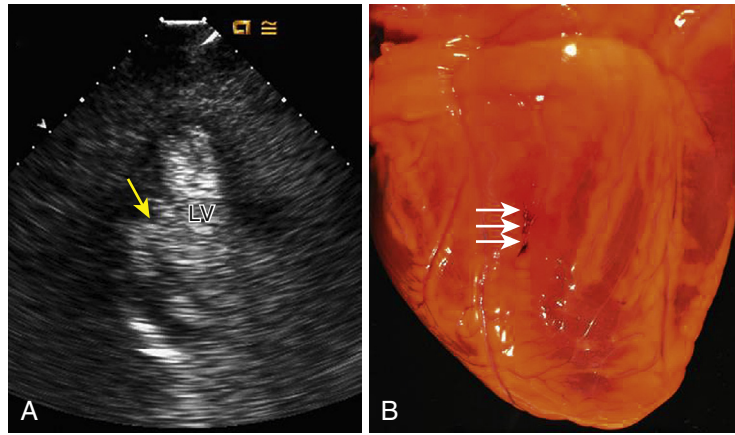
LV wall rupture, as demonstrated by A, extravasation of intravenous echo contrast from the LV cavity through a slitlike orifice (*arrow*) into the pericardium inferolaterally, on this apical three-chamber view. B, Posterior view of the heart, with the site of rupture (*arrows*) at the posterolateral left ventricle, causing this patient's demise 5 days after diagnosis of a large posterolateral myocardial infarction.
